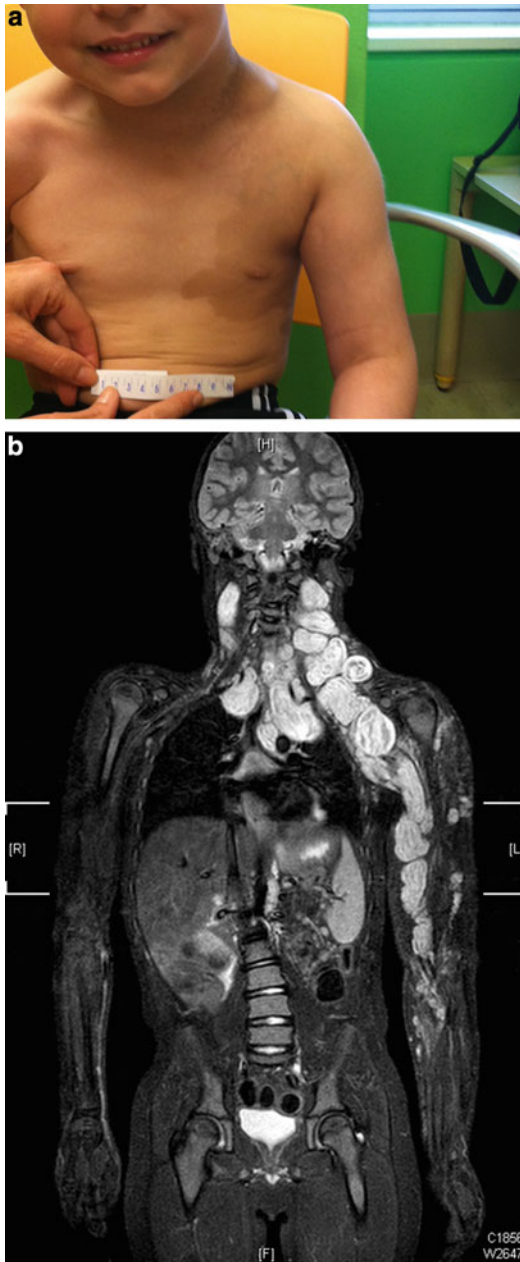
NF1 patient with a malignant peripheral nerve sheath tumor of the left arm (a) with accompanying MRI (b)
